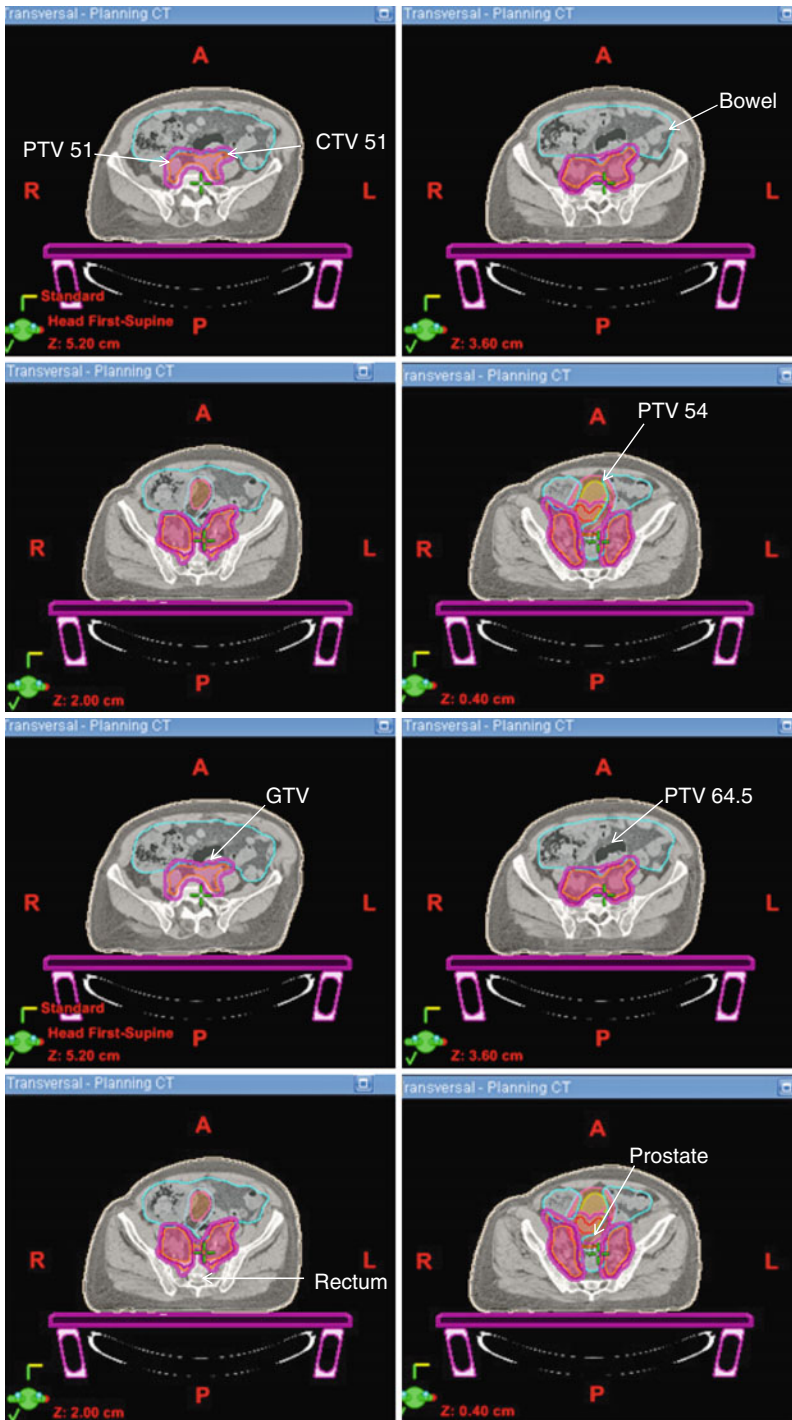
Axial CT slices with targets and critical structures contoured
